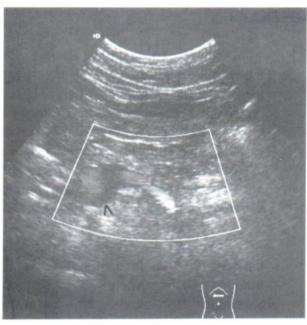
Transverse color Doppler ultrasound scan of epigastrium shows color in the normal sized splenic vein and 2.5 cm portal vein aneurysm (arrowhead).
